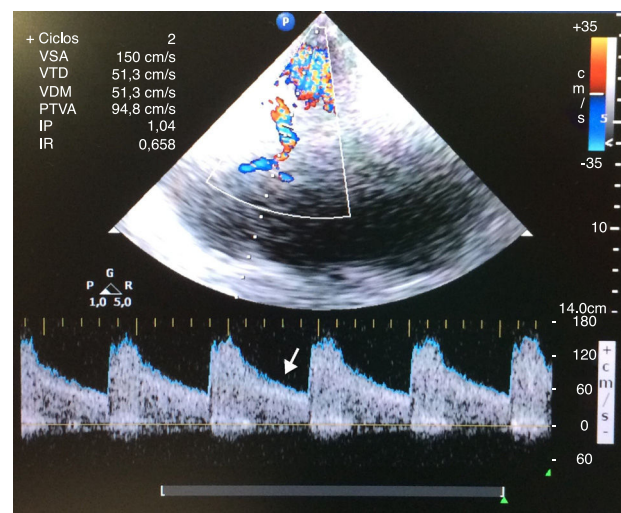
Transcranial color-coded duplex ultrasound recording. After evacuation of the pneumothorax, the diastolic wave was recovered in the left middle cerebral artery (white arrow).
